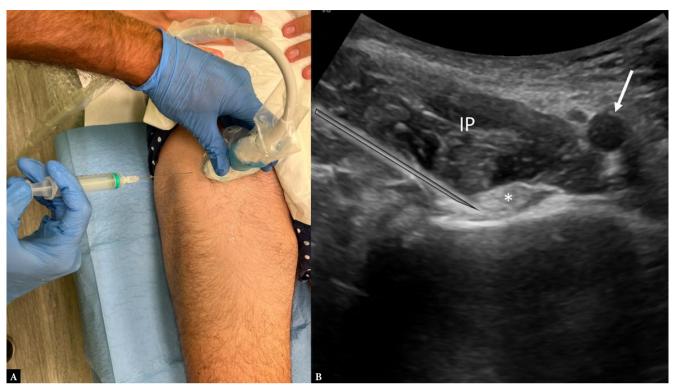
Ultrasound-guided iliopsoas injection. A. The patient is supine, and a linear transducer is positioned in transverse position at the level of the acetabulum to scan the iliopsoas tendon in the short axis. B. The corresponding ultrasound image shows how to insert the needle with in-plane lateral-to-medial approach to reach the deep aspect of the tendon (asterisk). With this approach, the femoral neurovascular bundle (arrow), in the medial aspect of the image, cannot be injured. IP – iliopsoas muscle
